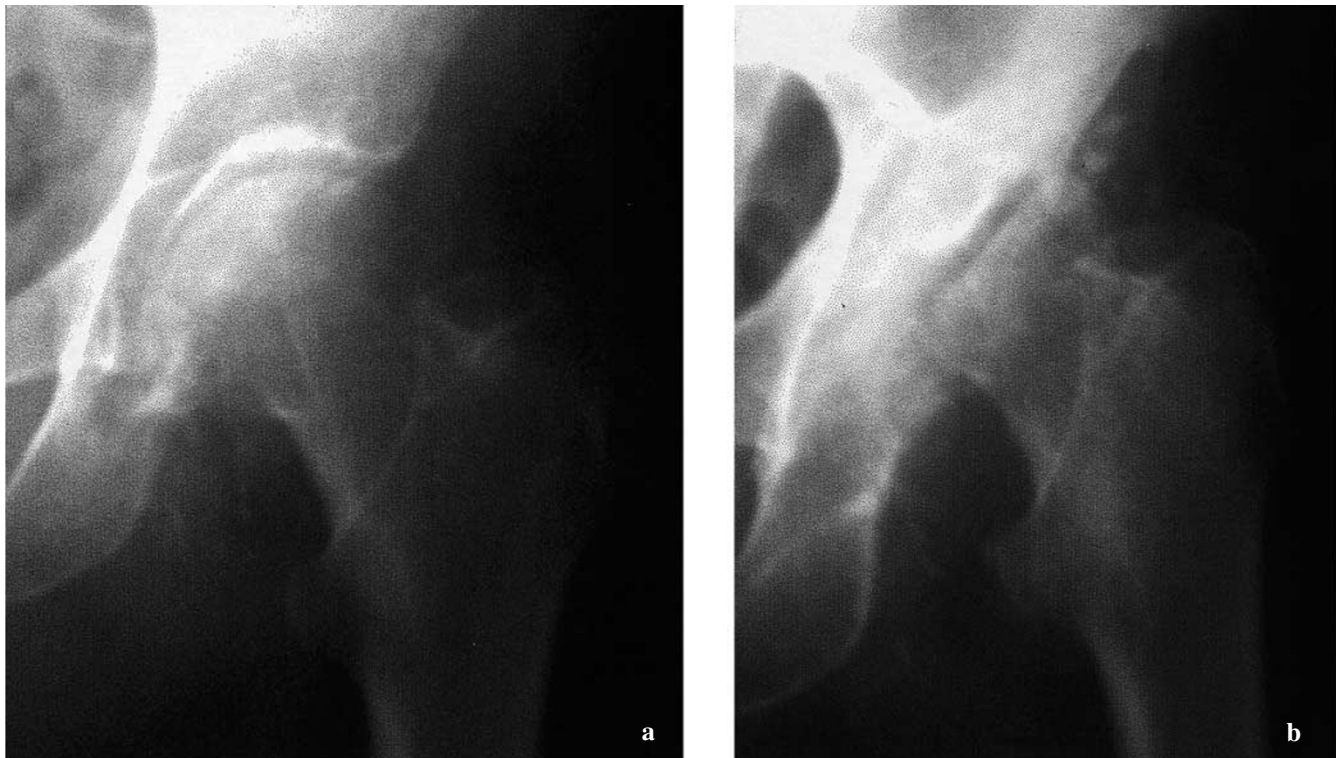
a Anteroposterior radiograph of the left hip in neutral position nine months after the surgical treatment of the right hip showed no abnormalities. b One month later, partial destruction of the left hip joint
